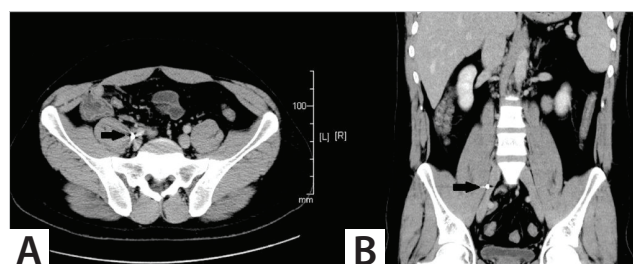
A. Axial and coronal B. Abdominal CT shows a posterior abdominal wall gunshot.
